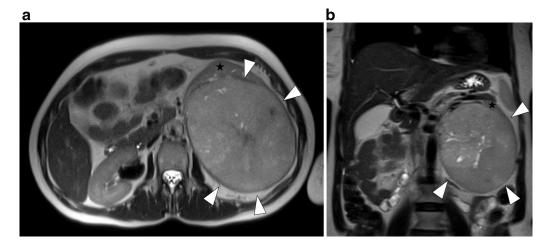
Pelvic MRI. Axial (a) and coronal (b) T2-WI show a hyperintense bulky left kidney mass. White arrowheads: renal cell carcinoma. Black star: renal parenchyma.
